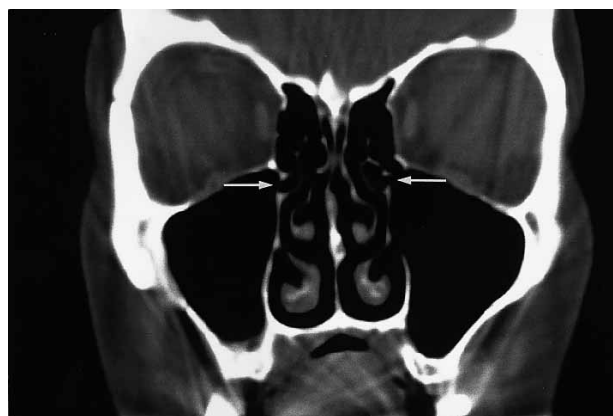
CT scan showing the high position of the paranasal ostium in the middle nasal meatus (white arrows).
